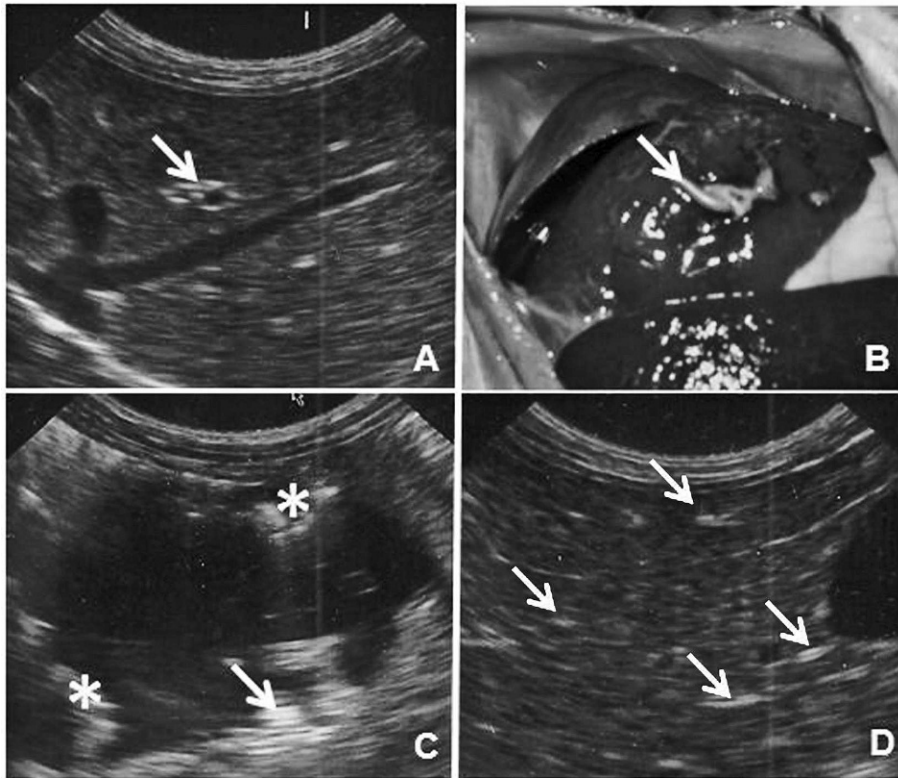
Ultrasound images of the liver (A, D) and stomach (C), and gross image (B) of *Gnathostoma turgidum*-infected Virginia opossums (*Didelphis virginiana*) from Sinaloa, Mexico, 2011. (A) The arrow shows a heterogeneous and hyperechoic area. (B) An apparent larval *G. turgidum* (arrow) in the liver of a hunter-killed opossum examined in March. (C) Irregular thickening of the gastric mucosa (asterisk) and foreign body mobility (arrow). (D) Healing areas (arrows) of regenerated liver. A, C, and D are the same opossum examined in March, July, and November 2011, respectively.
